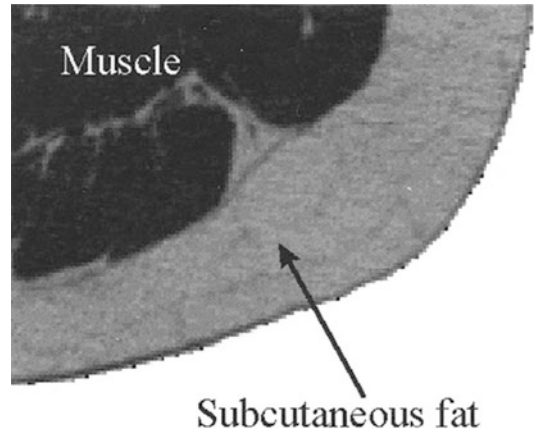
Computed tomography of the thigh. Part of cross-section with fat enhancement (Courtesy of Prof. Joffre, Radiology Department, Rangueil University Hospital, Toulouse, France)
